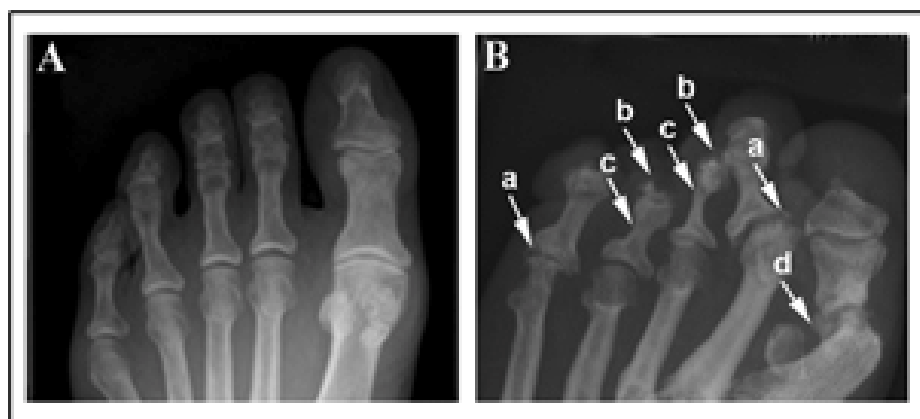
Bone erosions and acro-osteolysis in toes of the pycnodysostosis patient suffering from psoriatic arthritis. X-ray of normal toes (A) and of a pycnodysostosis patient from year 2005 (B). Panel B demonstrates patient’s foot with erosive changes in II and V MTP joints (a), complete resorption of the distal phalanges of digits III-IV (b) and partial resorption of the mid phalanges of digits III and IV (c). Also malunion after an attempted arthrodesis of the I MTP joint can be seen.
